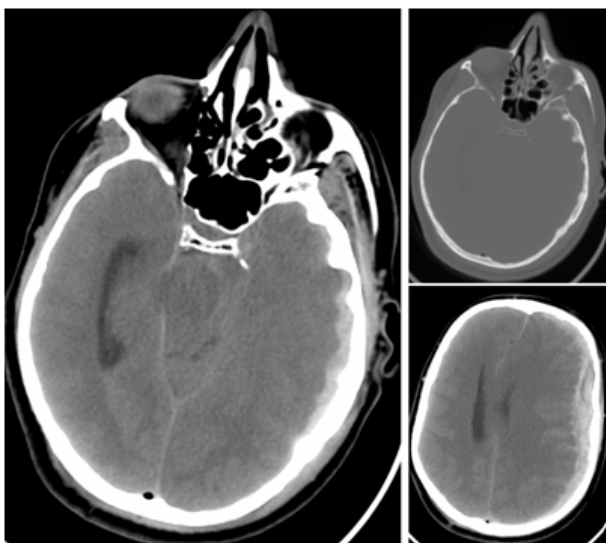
Cranial CT-scan, performed few minutes after the head injury, showing the large fronto-parietal acute subdural haematoma with the presence of air bubbles along the superior sagittal sinus.
